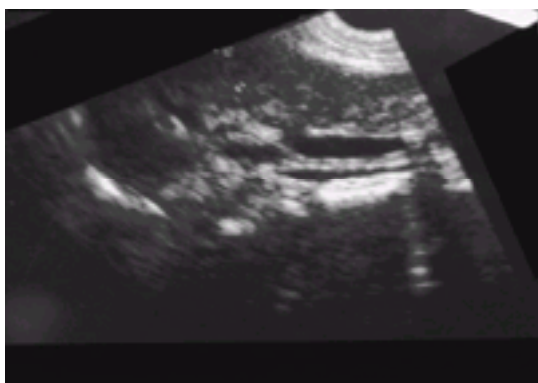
Ultrasonogram showing a gallstone in a dilated common bile duct; there is a typical sonic shadow behind the stone.
